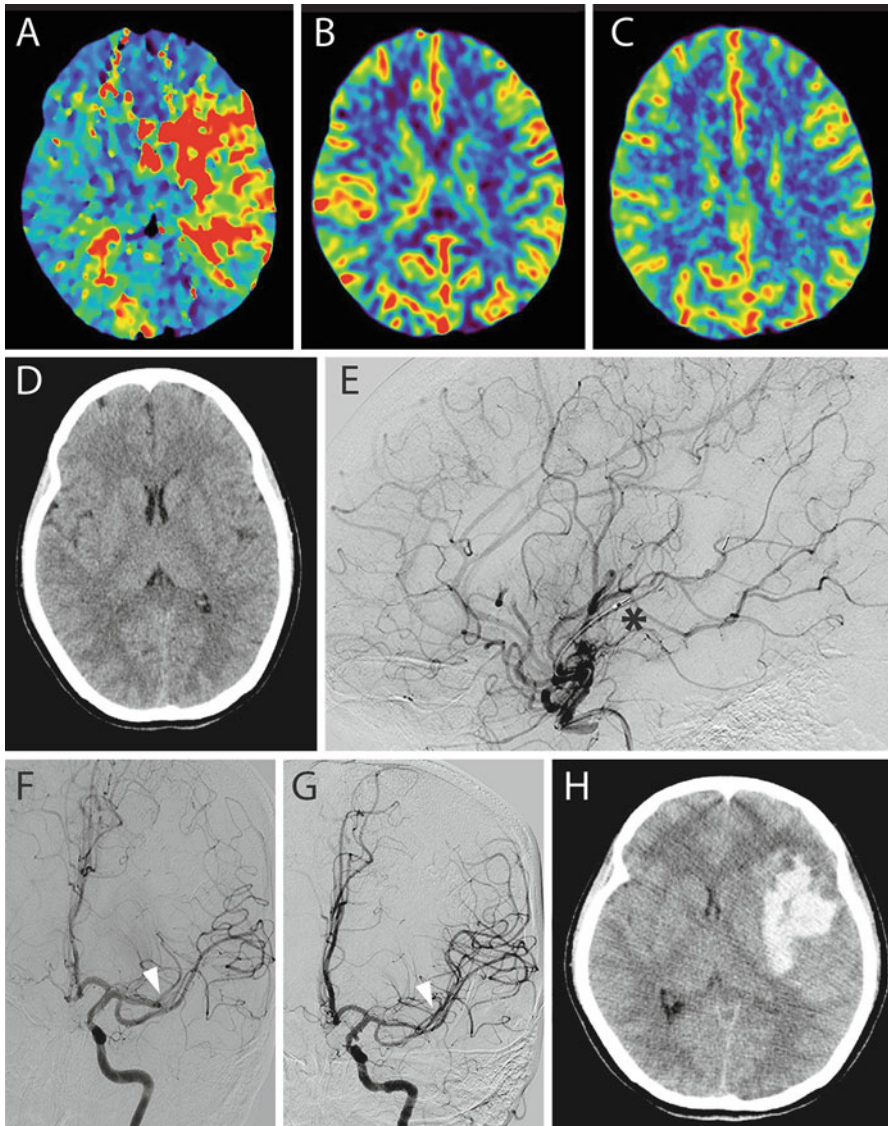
This 42-year-old patient presented 3 h after acute onset aphasia and right arm and leg hemiparesis. (a–c) Early CT perfusion demonstrated an elevated time to peak concentration (a) with minimal deficit in cerebral blood flow (b) or cerebral blood volume (c) suggesting good collateralization in the MCA territory. (d) Plain CT demonstrates early stroke in left insular cortex. The patient received 0.6 mg/kg of rtPA and was taken to the angiography suite. (e) A retrievable stent was deployed in the occluded M2 branch of the MCA (asterisk) and clot was retrieved. (f) Angiogram prior to stent retrieval shows M2 occlusion (arrow). (g) Angiogram following clot retrieval shows recanalization of the occluded M2 branch (arrow). (h) Nine hours after the procedure the patient declined with worsening weakness and decreased level of consciousness and was found to have an intracerebral hematoma in the distribution of the stroke. The patient went on to surgery to evacuate this clot without major clinical improvements postoperatively
